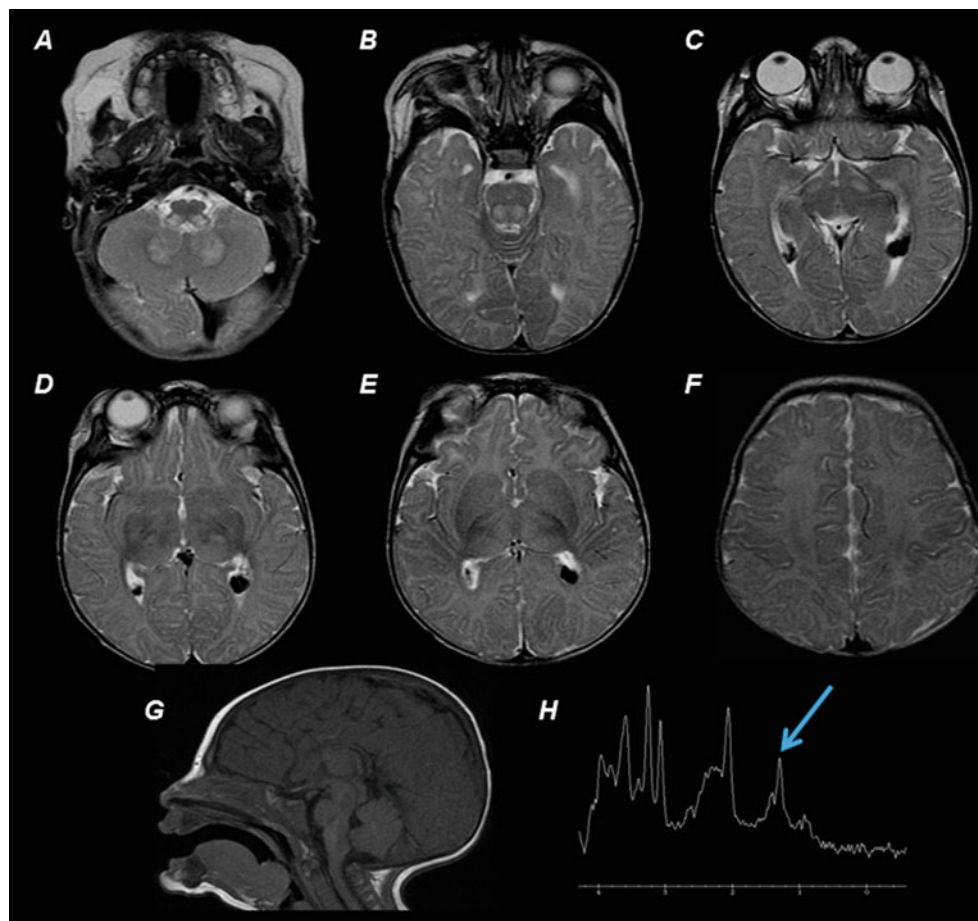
Brain MRI at 2 months old revealed bilateral and symmetrical abnormal high signal on T2-weighted images in the posterior part of the medulla oblongata and cerebellar white matter and dentate nucleus (a), posterior part of the pons (b), cerebral peduncles (c), subthalamus
